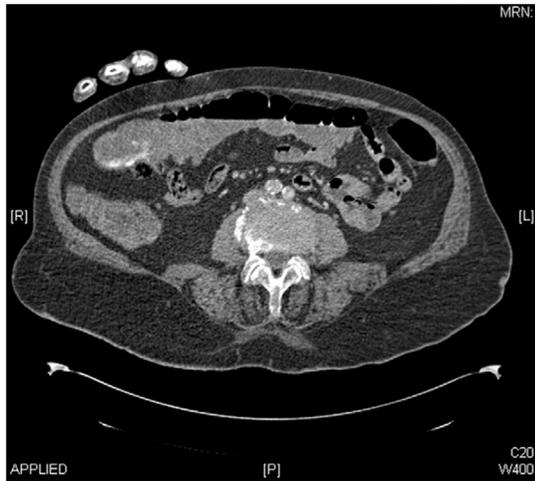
CT angiography showing a blush of intravenous contrast at a lower gastrointestinal bleeding point at hepatic flexure in a patient with acute colonic haemorrhage.
